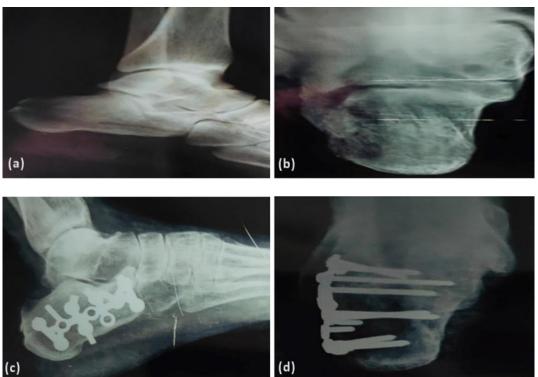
a) preoperative x-ray of calcaneum (lateral view) b) Axial view c) post-operative AP view of x- ray after 6-months of follow up d) axial view
